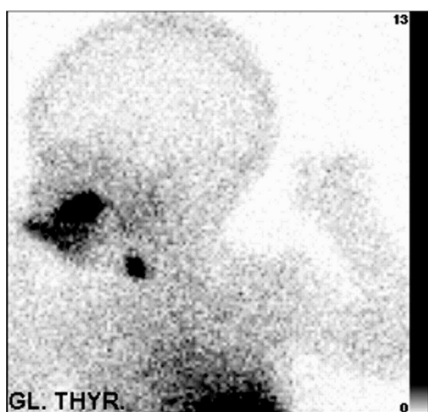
$^{99m}\text{Tc}$  pertechnetate thyroid scintigraphy demonstrating absence of thyroid uptake in a 10-day-old girl with congenital hypothyroidism due to thyroid agenesis (lateral and anterior view).
